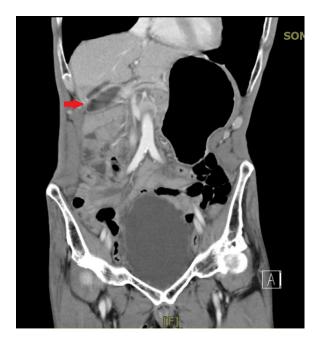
The coronal view of abdominal computed tomography demonstrated distended stomach and proximal duodenum and a lumen with fluid below gallbladder.
